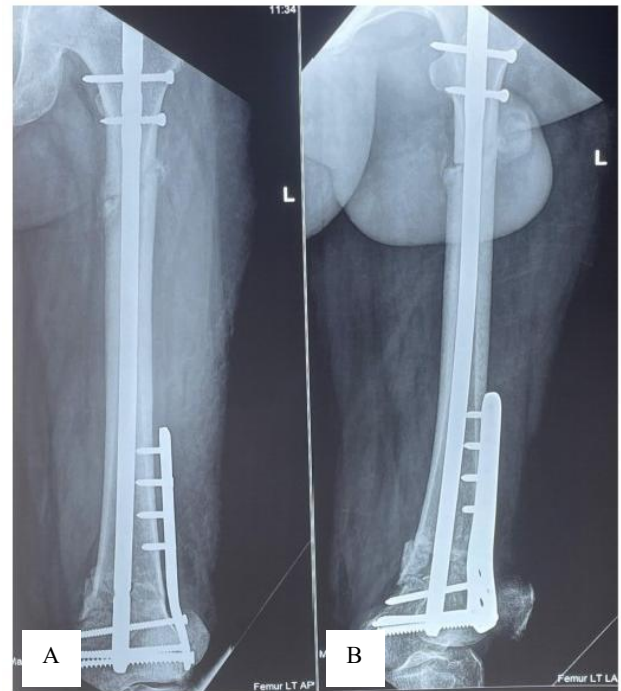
(A and B): Follow up X-rays left femur AP and lateral view at 6 weeks.
